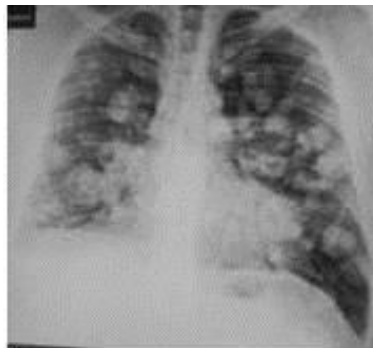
Chest X-ray: multiple bilateral pulmonary nodules at the central and subpleural levels, with air-bronchogram, and areas of ground-glass opacity
